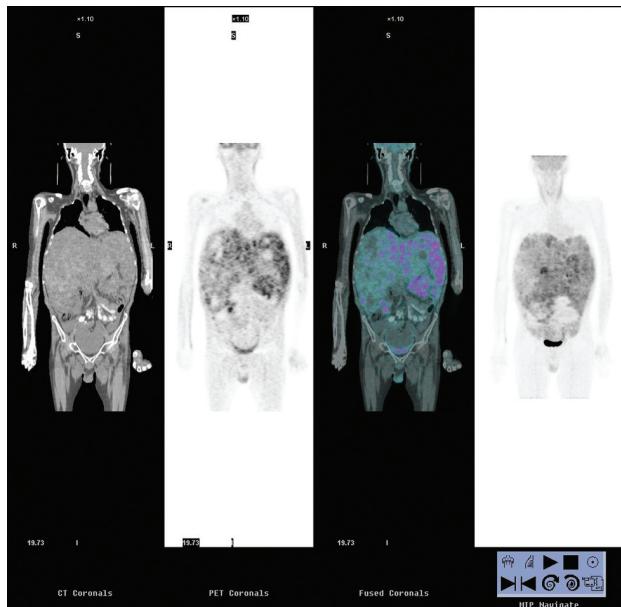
F-18 FDG PET/CT six weeks after the second therapy given to the left lobe (1.0 GBq) intra-arterially. The uptake of the right lobe was still significantly decreased. The uptake of the left lobe's lesions became less metabolic than before the therapy.
